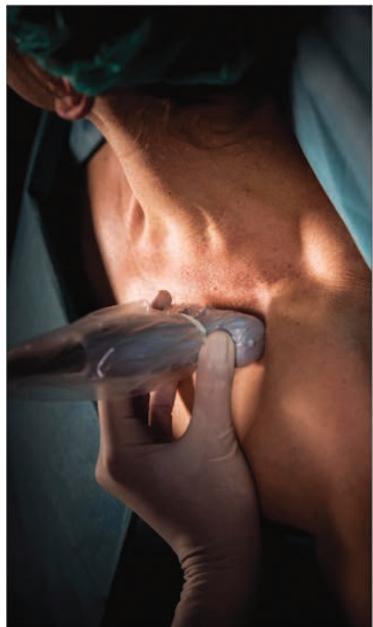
Transducer position and ultrasound image required for a costoclavicular block. AA, axillary artery; AV, axillary vein; MC, medial cord; LC, lateral cord; PC, posterior cord; R2, second rib.
